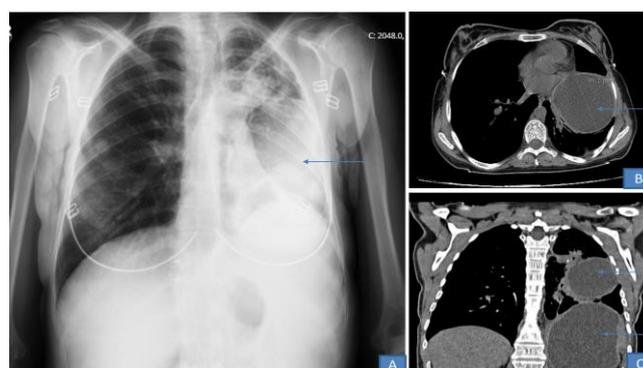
Posteroanterior chest X-ray (A), Thorax Computed Tomography cross-section (B), Thorax computed tomography coronal section (C)
